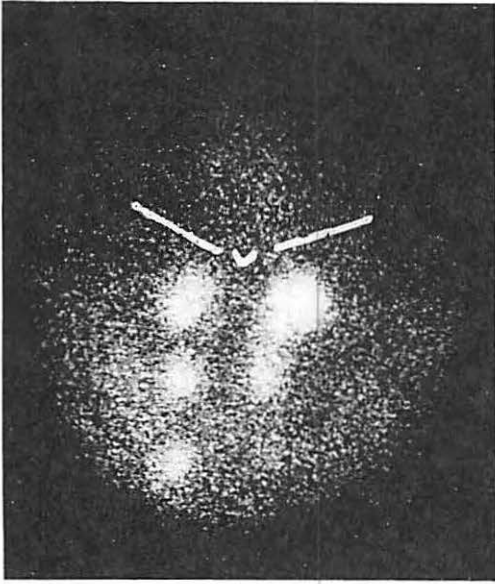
Parasternal lymphoscintigraphy 24 hours after bilateral suxiphoidal application of colloidal radiogold. Normal uptake in the lymph nodes of the first, second, fourth intercostal space (5).
